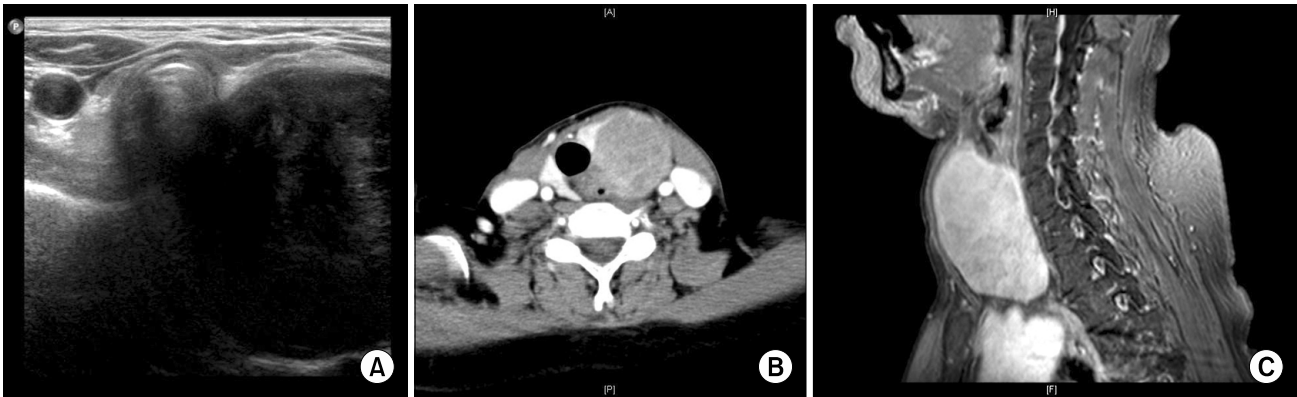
Preoperative imaging study. (A) Preoperative ultrasonography depicted a well-defined solid, hypoechoic mass in the inferior portion of the left thyroid. (B, C) CT and MR images showed an 8 cm sized solid mass in the left visceral neck space from the upper margin of the C6 spine to the lower margin of the T3 spine that mass abutted the trachea and the esophagus without invasion.
